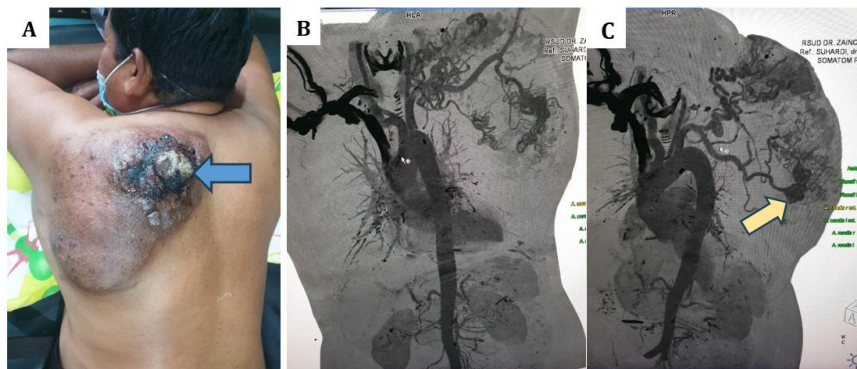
Clinical features of the patient. A) necrotic areas on the back region after arteriovenous malformations bleeding has stopped (blue arrow). B) and C) Computed tomography angiography of the back showing morphology of AVMs with multiple niduses (yellow arrow)
